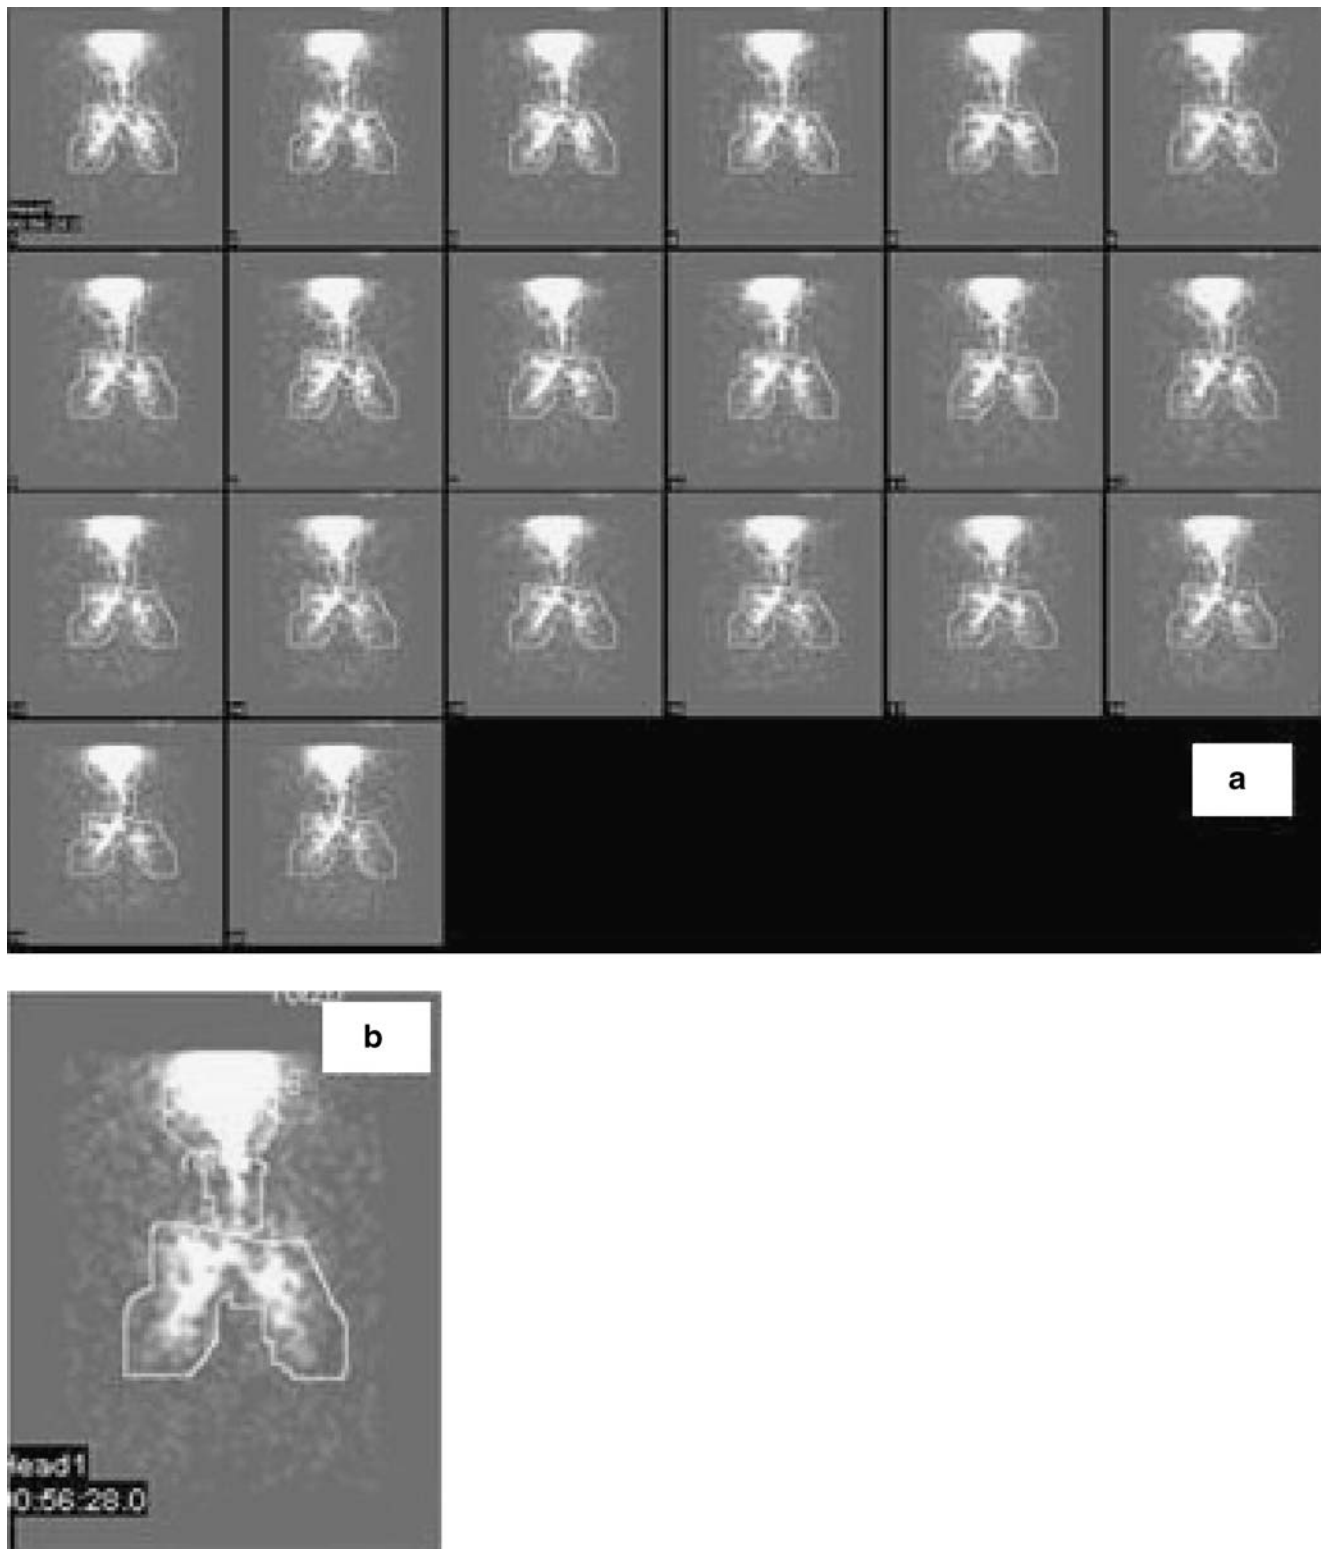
Scintigraphic image obtained with DPI: a for one representative volunteer, b scintigraphic scan after administration of BUD from DPI
